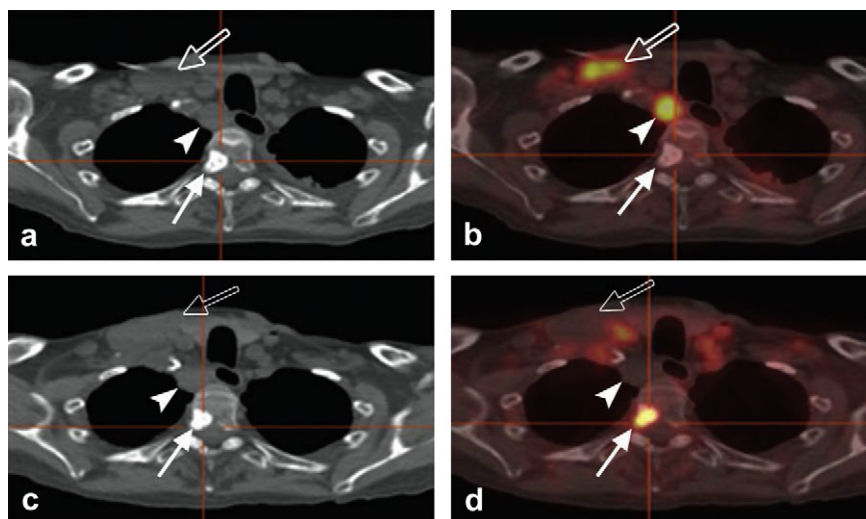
Images in a 75-year-old man with progressive metastatic prostate cancer starting protocol therapy with abiraterone acetate, an enzyme inhibitor that reduces blood levels of testosterone. (a) CT component of FDG-PET/CT, (b) fused FDG-PET/CT, (c) CT component of FDHT-PET/CT, and (d) fused FDHT-PET/CT images show a sclerotic vertebral lesion (solid arrow) as well as right supraclavicular (open arrow) and retrotracheal (arrowhead) lymphadenopathy. Image b demonstrates increased glycolysis in the retrotracheal and right supraclavicular lymphadenopathy but no uptake in the vertebral bone lesion. Conversely, d demonstrates increased uptake in the vertebral bone lesion but no uptake in the retrotracheal and right supraclavicular lymphadenopathy. Biopsy of the retrotracheal node yielded a finding of “large cell” malignancy, favoring carcinoma, without further classification. This case demonstrates the phenomenon of discordant tumor biology between lesions. (Reprinted from Hricak H. *Oncologic imaging: a guiding hand of personalized cancer care*. *Radiology*. 2011 Jun; 259(3):633–640).
